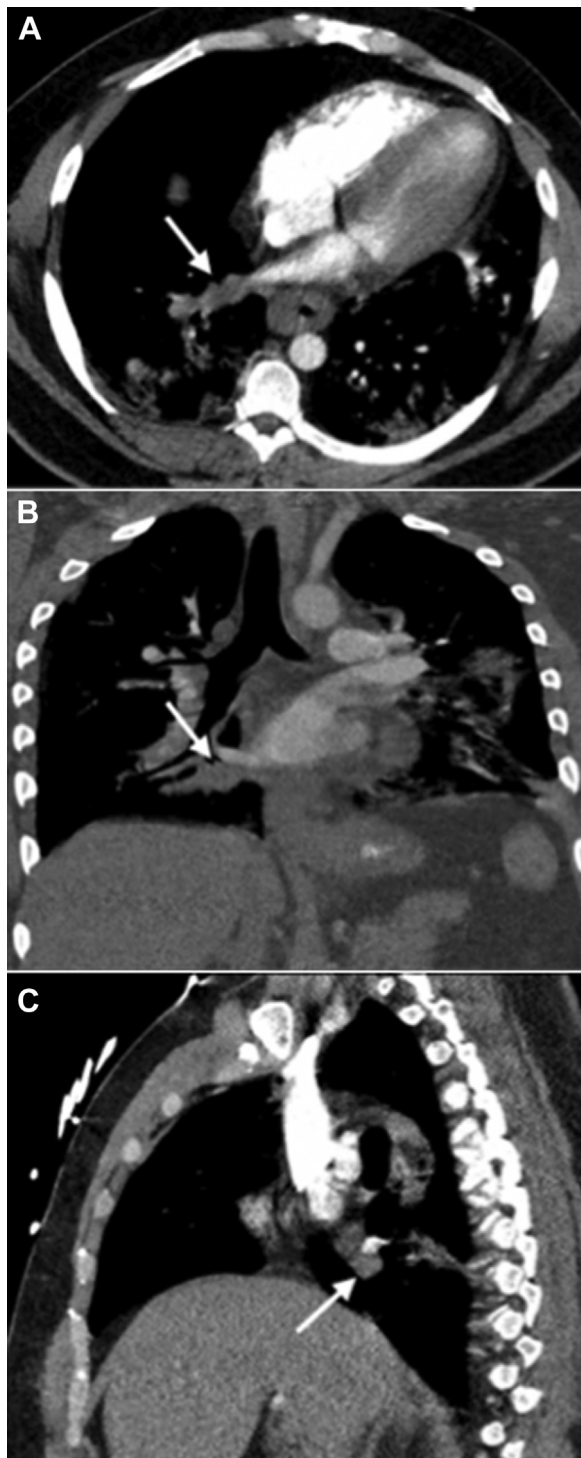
A, Axial, B, coronal, and C, sagittal contrast enhanced CT images of the chest: filling defect with focal distention of a branch of the right inferior pulmonary vein (white arrows), consistent with occlusive pulmonary venous thrombosis.
